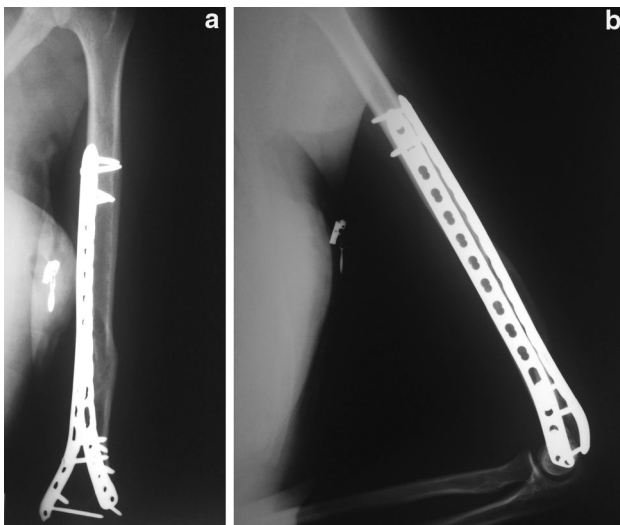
Radiographs of the humerus following open reduction. Anteroposterior (a) and lateral (b) radiograph demonstrating plate position and bone callus
